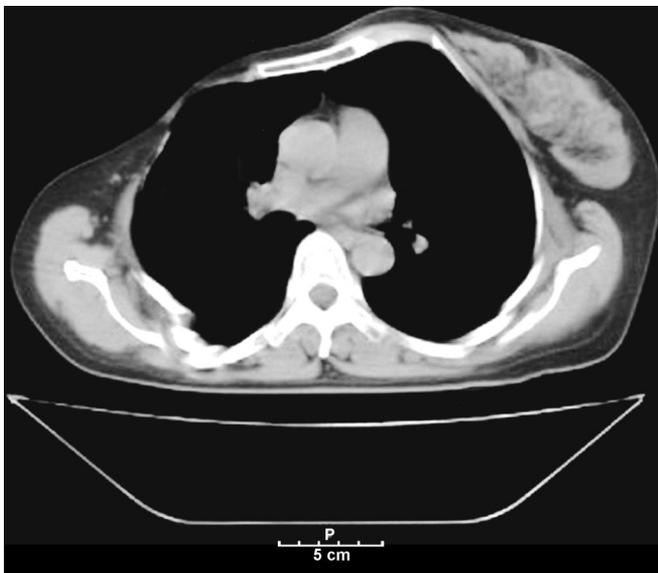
Axial computed tomography section of the thorax revealing thinned chest wall with hypoplastic breast and aplastic pectoral muscles and associated skeletal anomalies consisting of mild rotation of the sternum and carinatus deformity.
